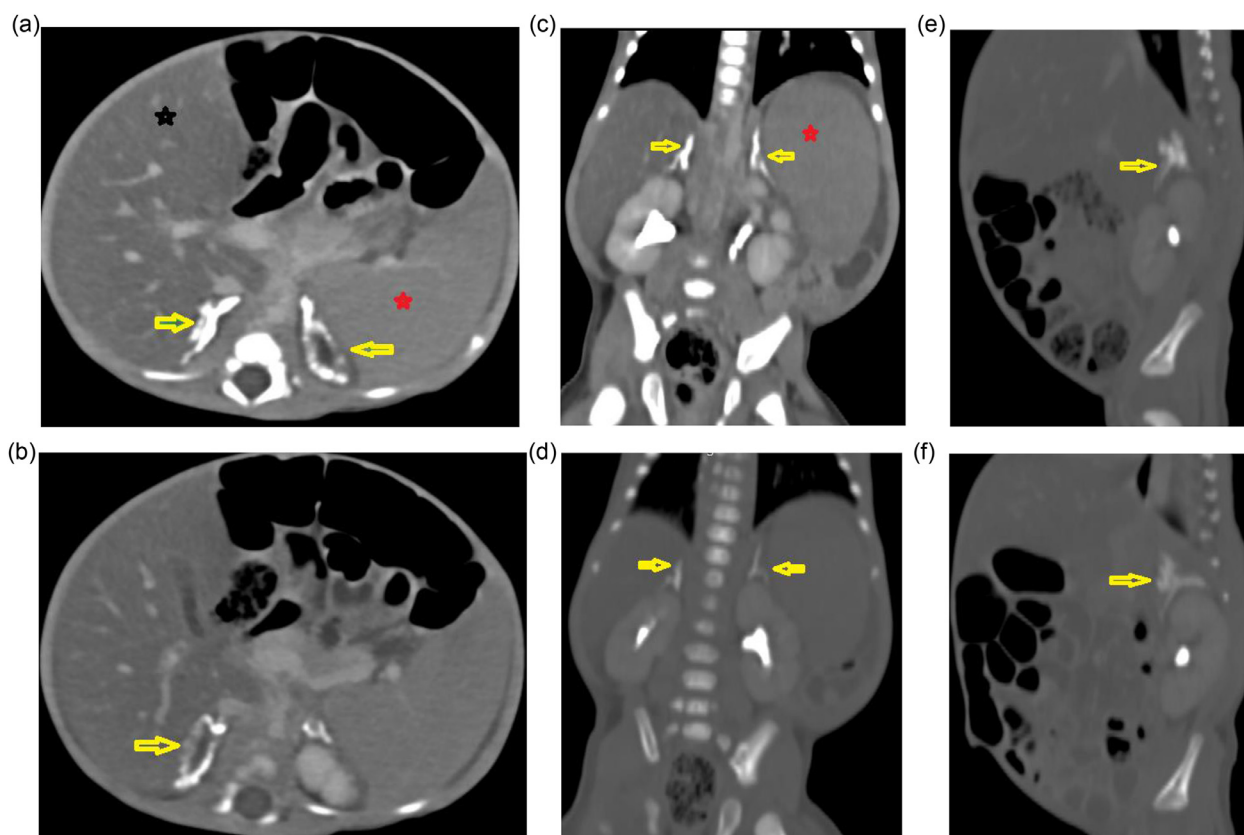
(A-F): Selected axial, coronal and sagittal contrast-enhanced abdomen CT scan soft tissue and bone window images demonstrating demonstrating enlarged adrenal glands with stippled cortical calcifications preserving their adreniform shape (yellow arrows), fatty liver (black asterisk), and enlarged spleen (red asterisk). (Color version of figure is available online.)
